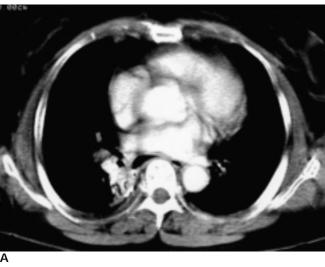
Esophagobronchial fistula with unknown cause in a 72-year-old-woman. A. CT scan shows previously ingested barium-containing consolidation in the right lower lobe.
